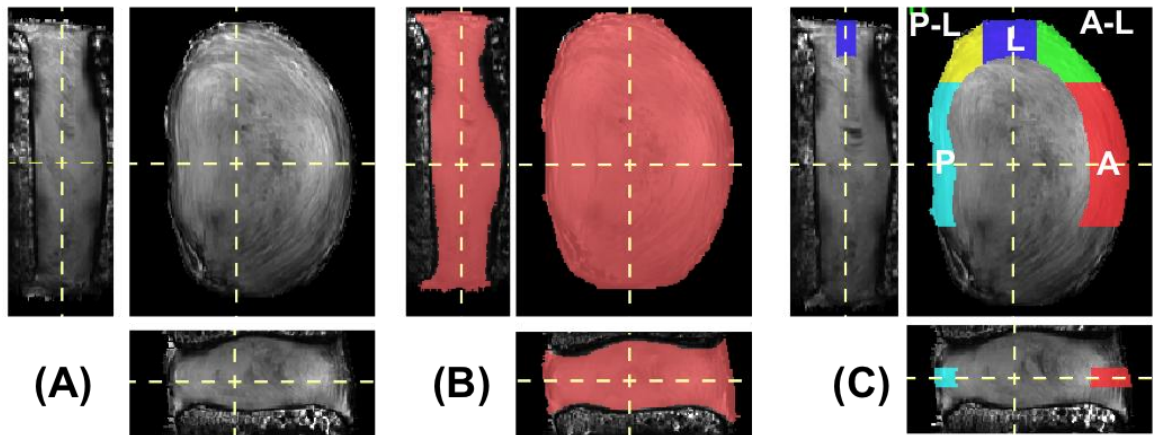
Images (A – C) are oriented to show coronal (left), axial (top-right), and sagittal (bottom) planes. (A) Representative MRI data set. (B) The volume used for strain analysis (pink). (C) Annulus fibrosus regions of interest defined in the mid-axial plane: A=anterior (red), A-L=anterior-lateral (green), L=lateral (purple), P-L= posterior-lateral (yellow), P=posterior (aqua).
